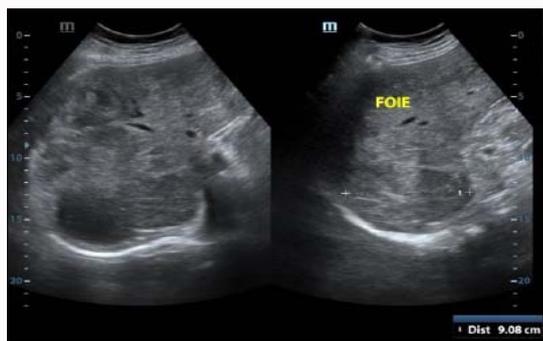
Ultrasound of the liver.
